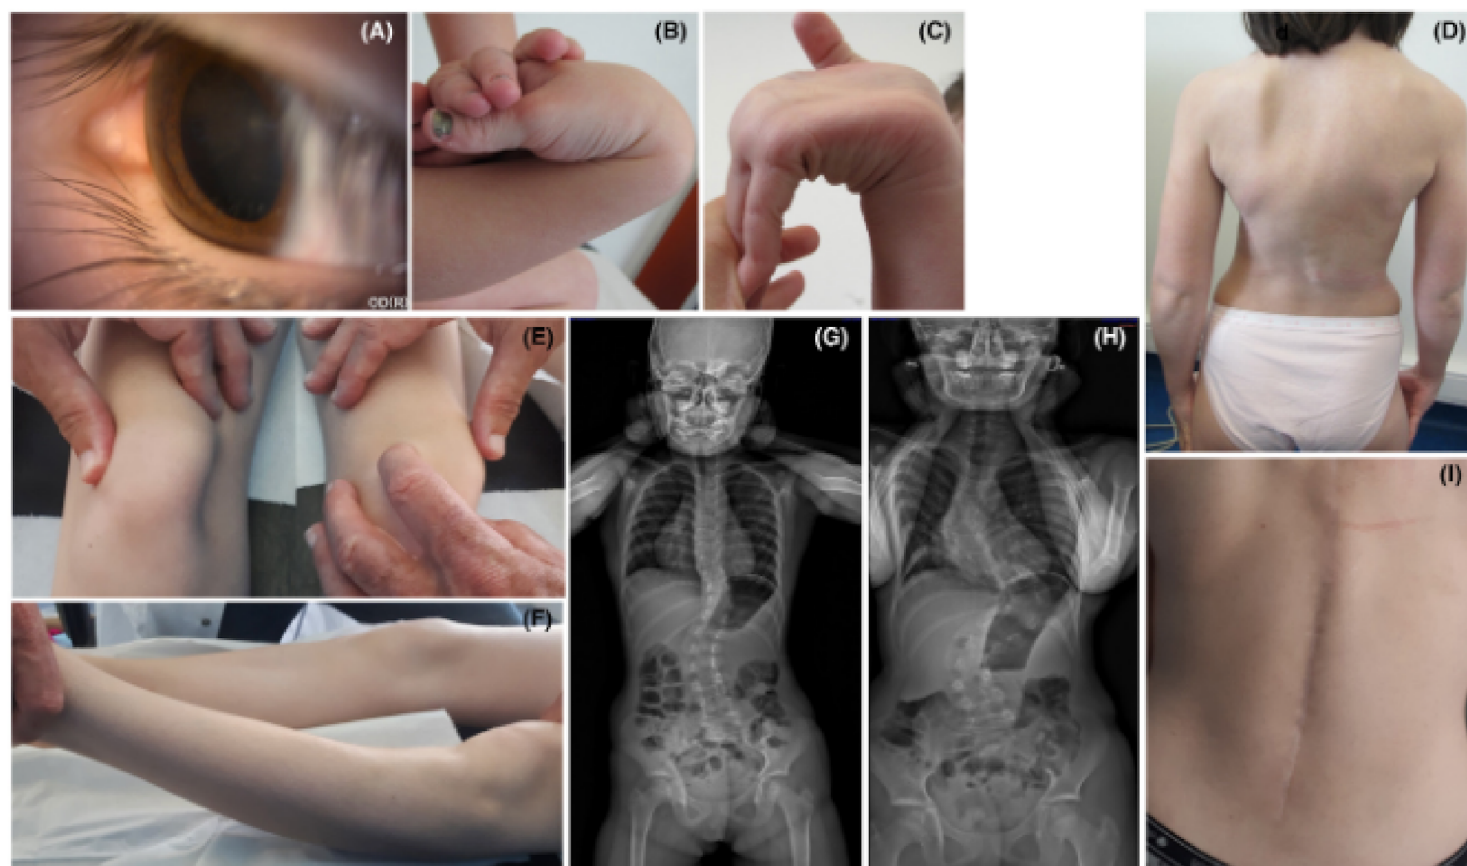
Clinical and radiological findings of the patient. (A) Corneal thinning with keratoglobus at slit lamp examination. The patient at age of 9 years presented joint hypermobility: (B) joint hypermobility of the thumb (Positive apposition of thumb on the forearm), (C) joint hypermobility of the wrists and fingers, (D) marked dorsal gibbosity, (E) hypermobility of patella, and (F) genu recurvatum, (G, H) 2D anteroposterior X-rays view at 6 and 12 years, respectively. (I) At the age of 14, she had a normal scar resulting of the arthrodesis correcting the spine.
